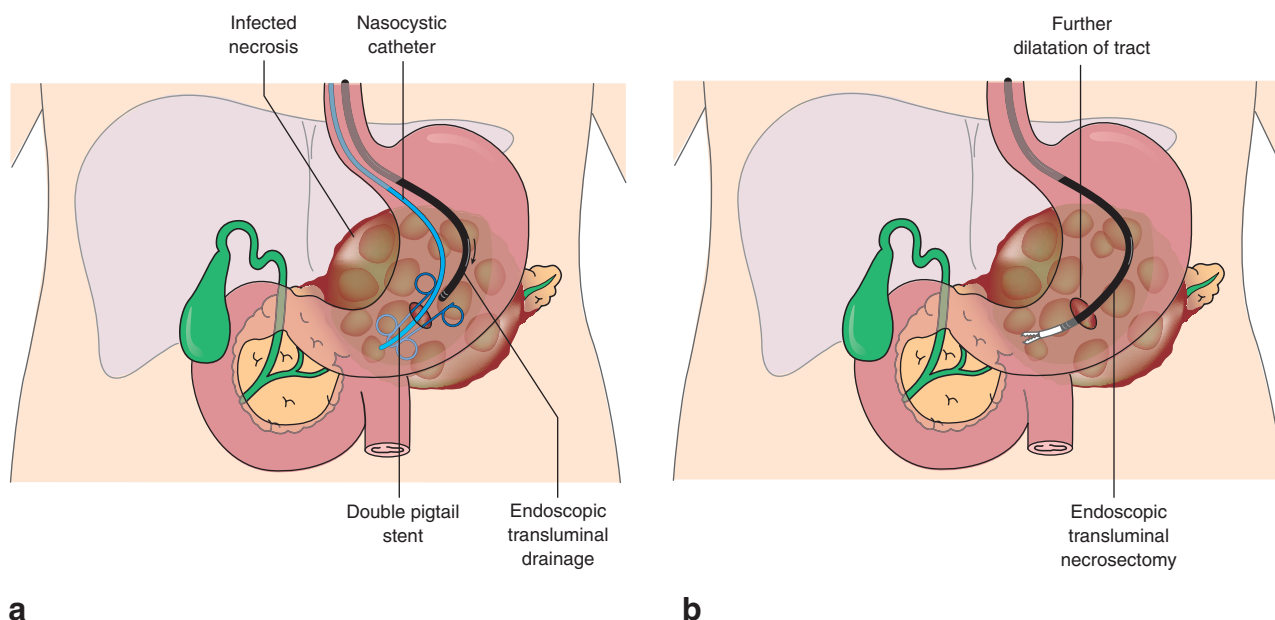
Under direct vision or endosonographic guidance, the gastric or duodenal wall is punctured to evacuate the infected necrotic material. a After serial dilatation of this transmural tract, two double-pigtail catheters are placed to establish a patent drain tract. b Should the need for endoscopic necrosectomy arise, the tract is dilated further so that various endoscopic necrosectomy instruments can be introduced
